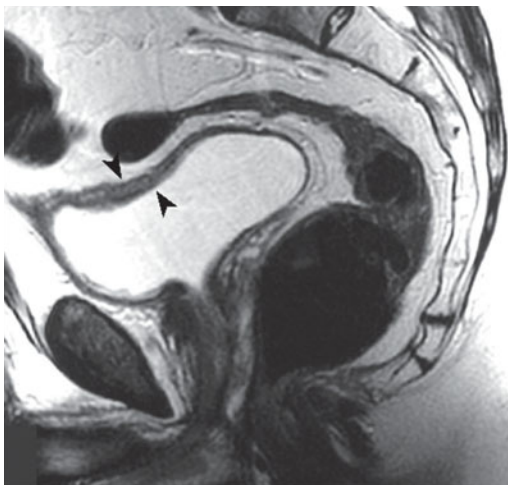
Magnetic resonance. Urinary bladder. Axial T2-weighted image. The different layers making up the bladder wall can be distinguished (*arrowheads*)
